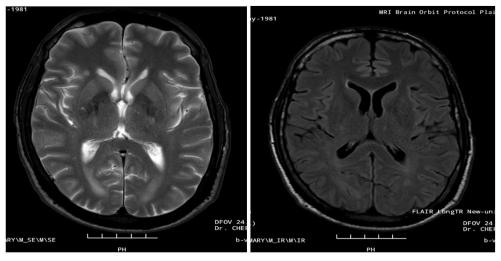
MRI Images showing FLAIR
